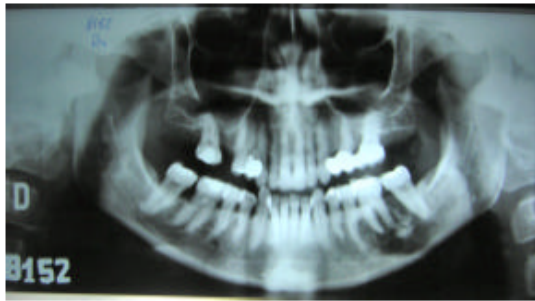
Orthopantomography shows extension of bony sequestrum
